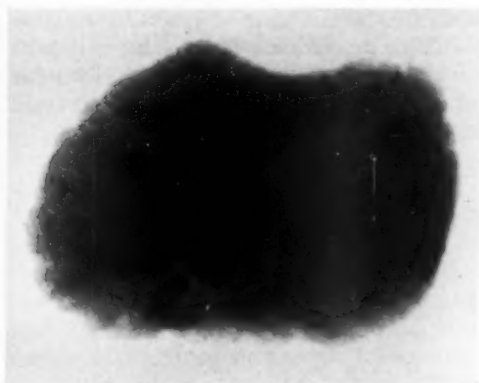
Roentgenogram of large cystine calculus.
